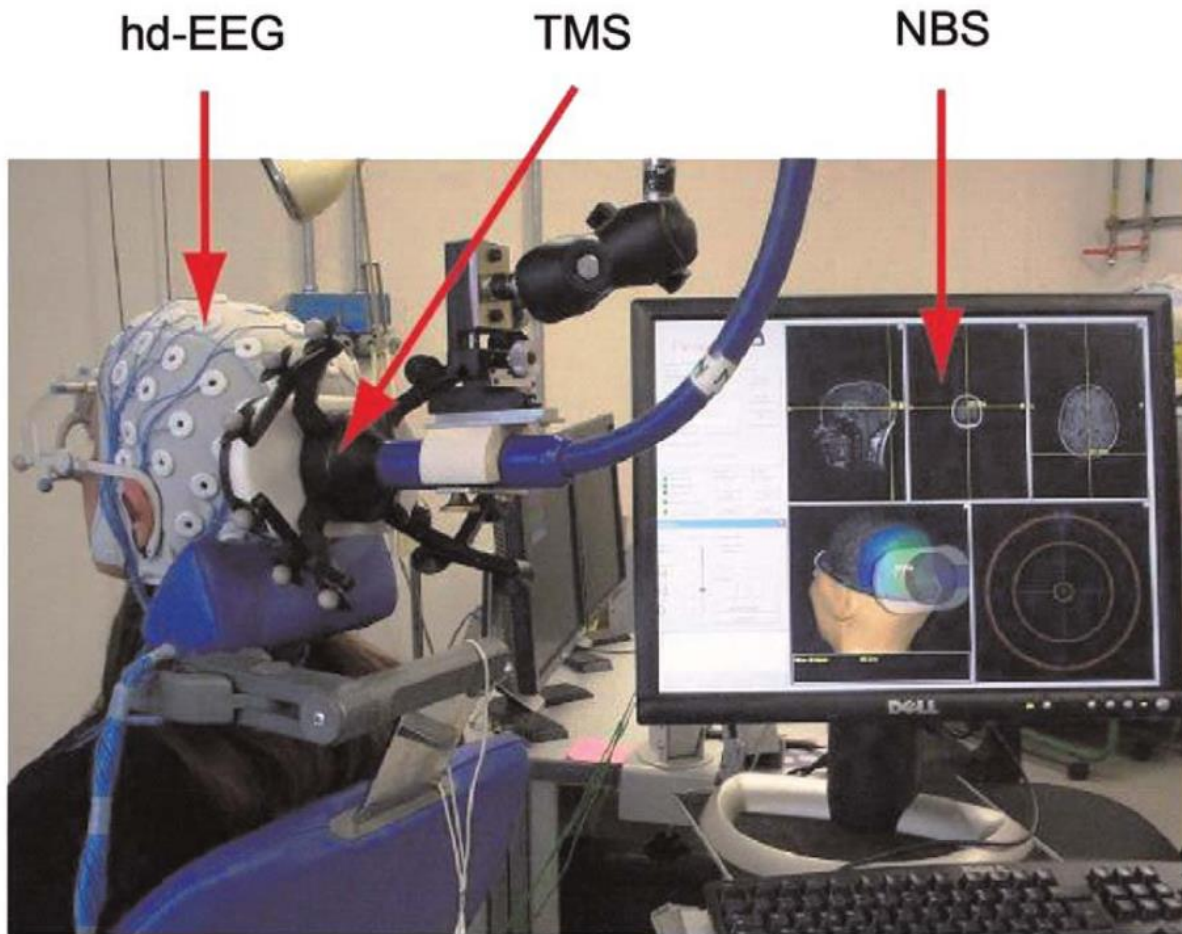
TMS/EEG setup. In this example, a subject is sitting on ergonomic chair while TMS is targeted to occipital cortex. The red arrows indicate, from left to right, the three fundamental elements that compose the set-up: (1) a cap for high-density (60 channels) EEG recordings (hd-EEG) that is connected to a TMS-compatible amplifier; (2) a focal figure-of-eight stimulating coil (TMS), held in place by a mechanical arm; (3) the display of the navigated brain stimulation system (NBS). This system employs an infrared camera (not visible in this picture) to navigate TMS on a 3D reconstruction of the subject's MRI. The location and the intensity of the electric field induced by TMS are estimated and displayed in real time. To prevent the subject from perceiving the click associated with the coil discharge, noise masking is played through inserted earplugs.
